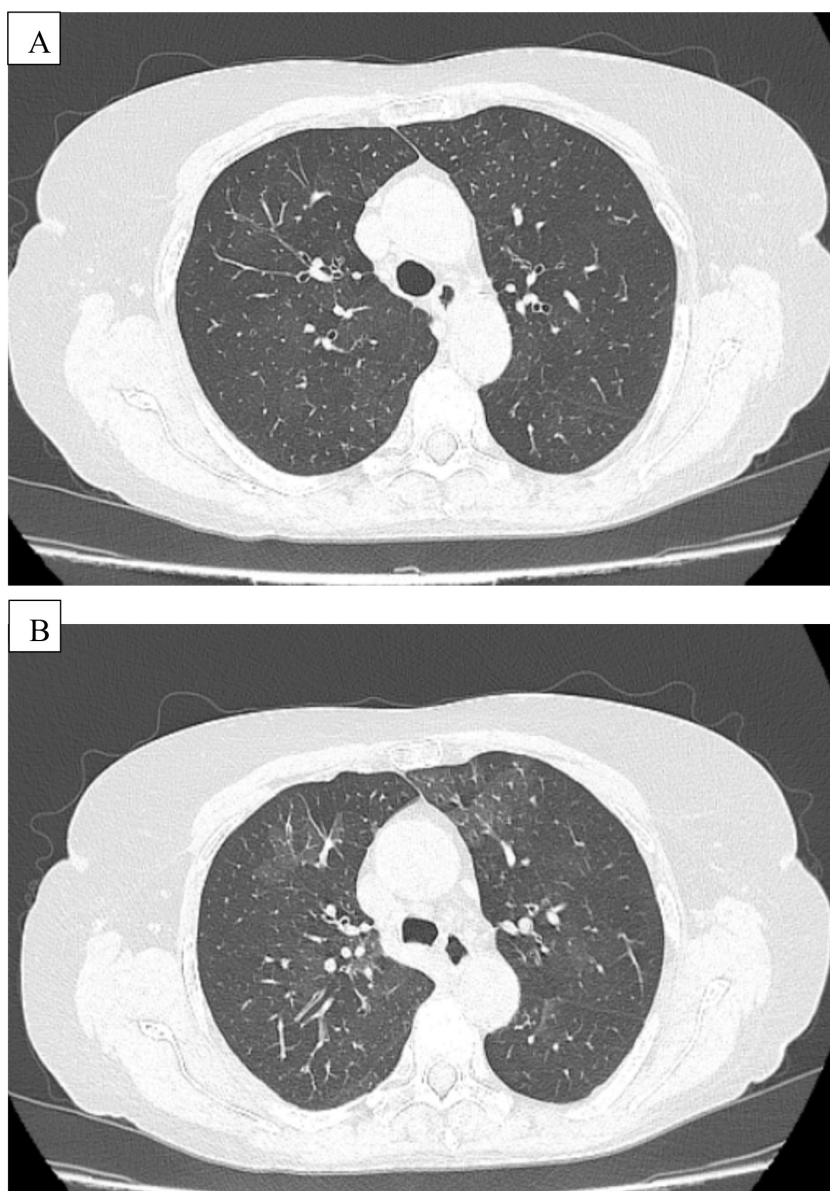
HRCT - Bilateral diffuse mosaic attenuation patterns representing air trapping and normal parenchyma more pronounced on expiration (B) than on inspiration (A).
